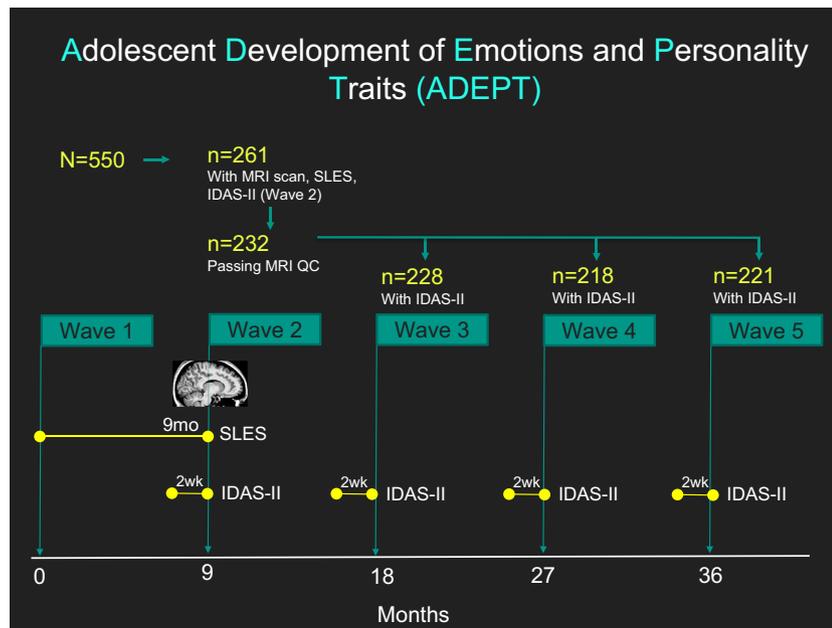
Timeline for the Adolescent Development of Emotions and Personality Traits (ADEPT) study as relevant to the present analysis. IDAS-II, Inventory of Depression and Anxiety Symptoms II; MRI, magnetic resonance imaging; QC, quality control; SLES, Stressful Life Events Schedule.
